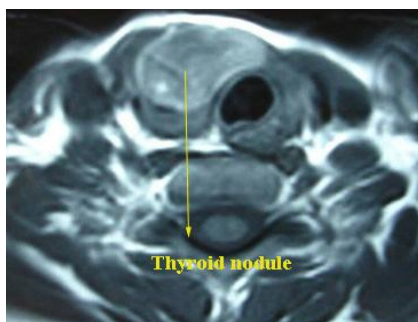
CT scan showing thyroid nodule
